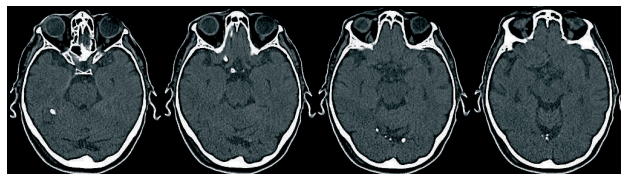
CT scan prior to admission: hyperdense images consistent with dystrophic calcification in the free edge of the cerebellar tentorium.
